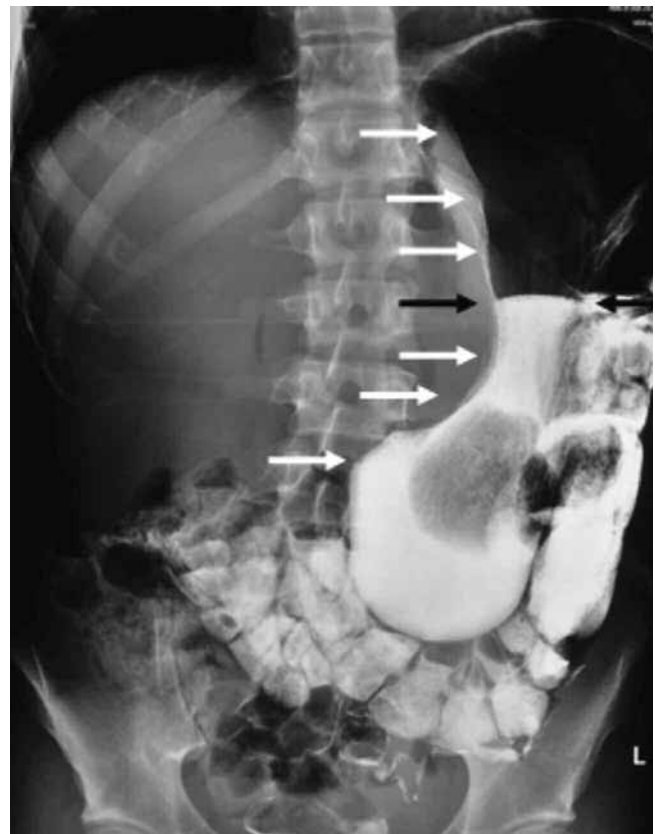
Abdominal X-ray following the contrast barium enema study in upright position. It shows a large structure (white arrows) with contrast due to communication with the transverse colon with air-fluid level (black arrows).
